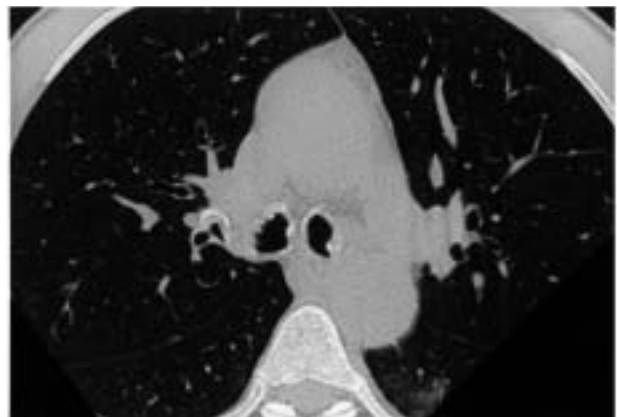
Computed tomography (CT) scan, just below the main carina.
